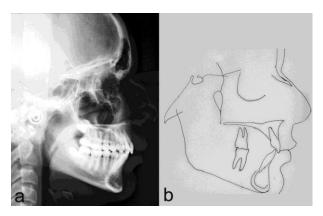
a) Lateral head radiograph after therapy; b) cephalometric tracing after therapy.
